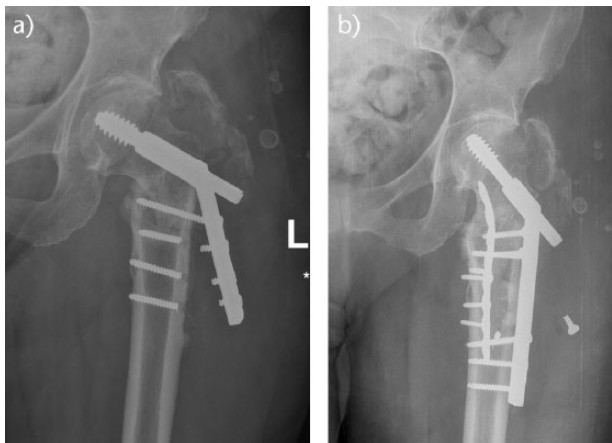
Radiographs showing loss of femoral offset: a) failed dynamic hip screw with loss of the medial buttress and over dynamisation and b) Endosteal plating as described originally by Geoff Mast. The calcar is restored and the fracture heals.
